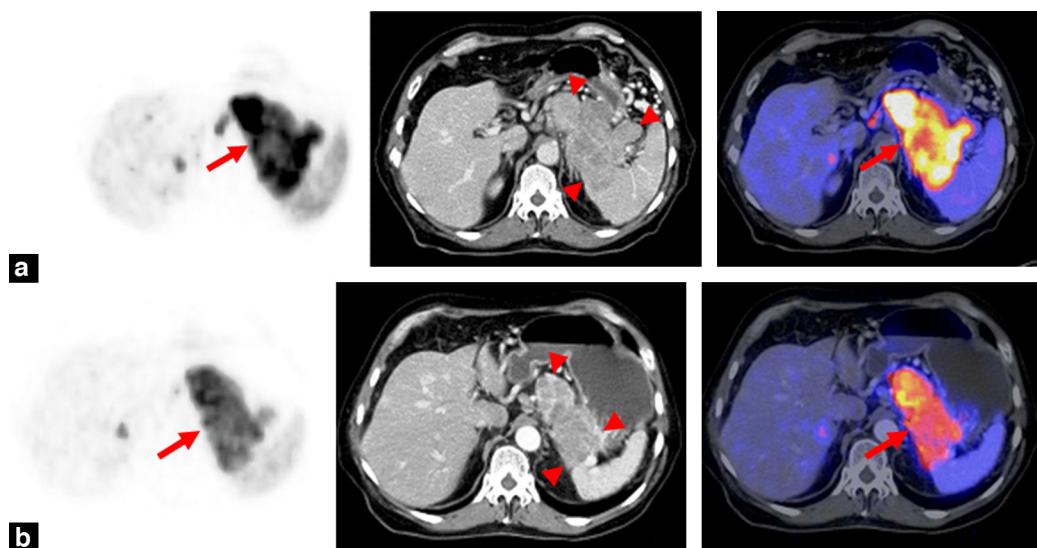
Responder to peptide receptor radionuclide therapy (PRRT). A 63-year-old man with metastasized neuroendocrine tumor of the pancreas (PET, CT, and Fusion). Before (a) and after (b) PRRT with 3730 MBq ^{90}Y -DOTATOC. Post-therapeutic decrease of ^{68}Ga -DOTATOC uptake (arrows), reduction of tumor size (arrowheads), falling tumor markers and improving general condition with weight gain reflecting good treatment response. Pre-therapeutic ^{68}Ga -DOTATOC uptake was 53.3; pre-therapeutic assumed ^{90}Y -DOTATOC uptake was 2.2 MBq/g.
